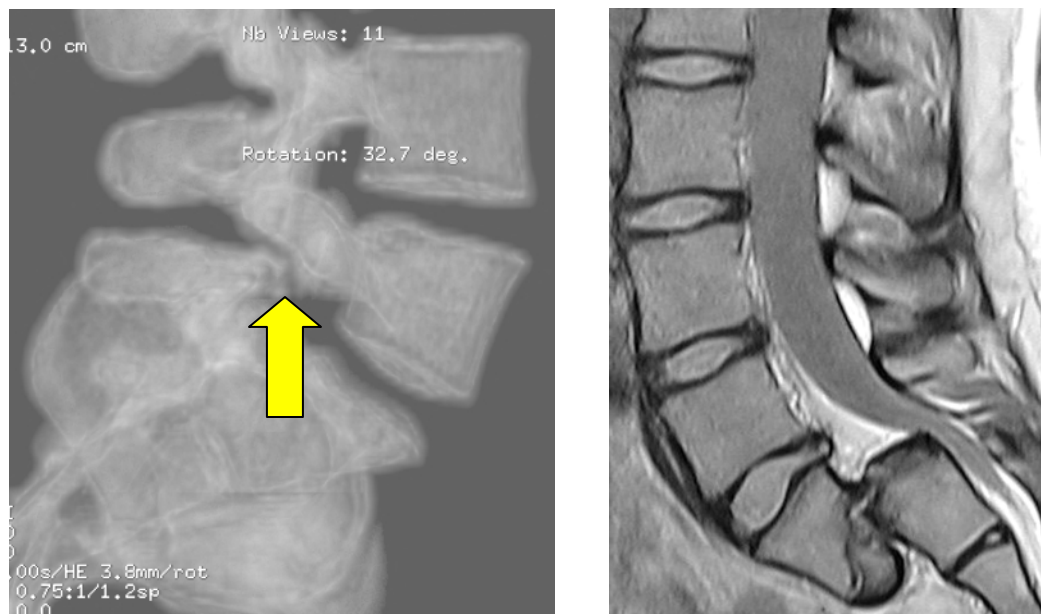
CT scan with 3D reconstruction of L5 spondylolysis
